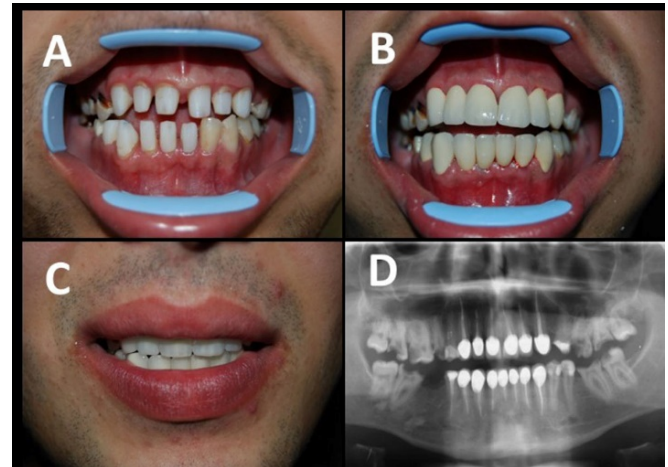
The stages of prosthetic treatment, (A): Tooth preparation, (B): Cementation, (C): Smile line after treatment, (D): Radiographic examination after treatment.
